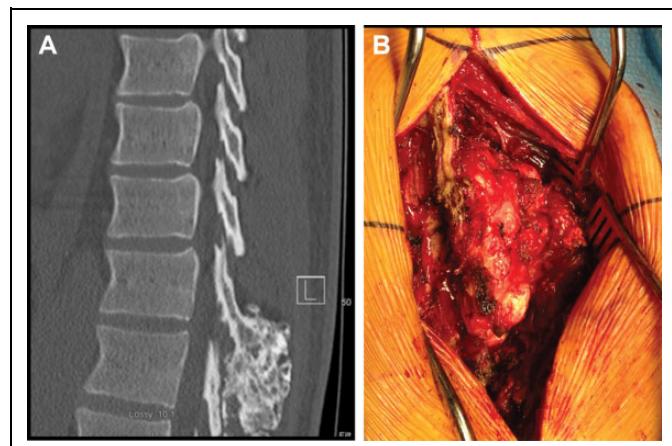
A 35-year-old male with mid-back pain following a minor injury. Plain radiographs demonstrated a mass arising from the posterior elements of T12. (A) Mid-Sagittal computed tomography scan of the thoracic spine demonstrating an osseous mass at the thoracolumbar junction. (B) Intraoperative clinical photograph of well-encapsulated thoracic mass.
